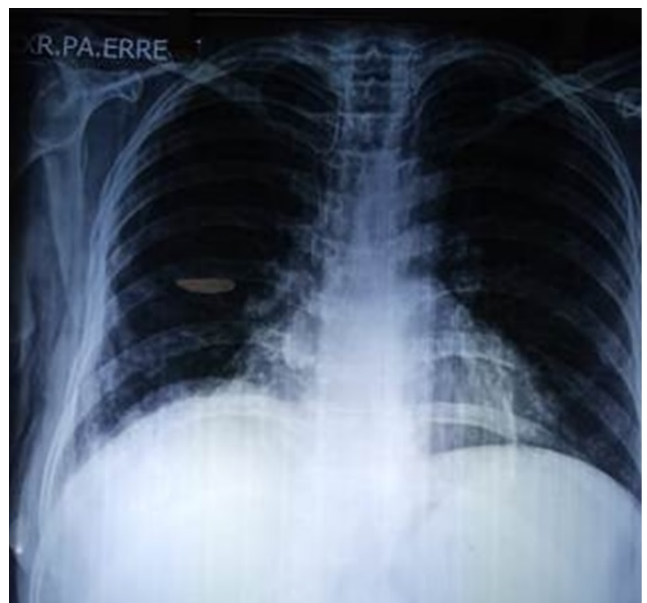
Chest X-ray after treatment shows complete resolution of pleural and pericardial effusions.
